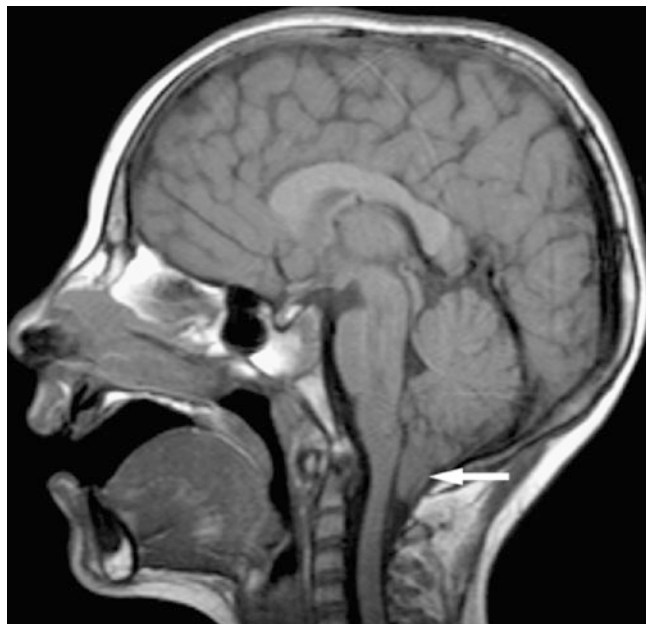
Chiari malformation type I; 7-year-old female with Noonan syndrome presents with neck pain. Mid-sagittal T1-weighted MRI shows descent of point of tonsils through the foramen magnum (*arrow*) and the absence of CSF in cisterna magna
